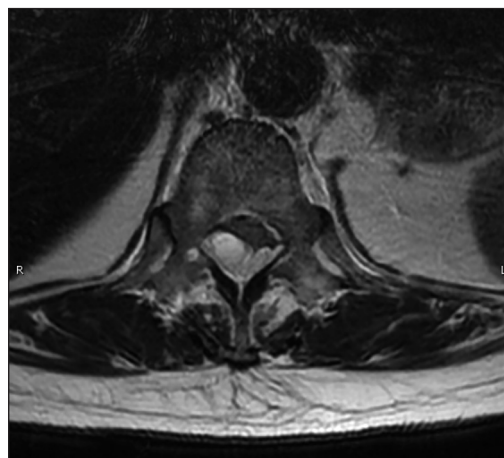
Magnetic resonance images of the T12 axial T2-weighted image show a predominantly hyperintense posterior extradural mass that compressed the spinal cord
